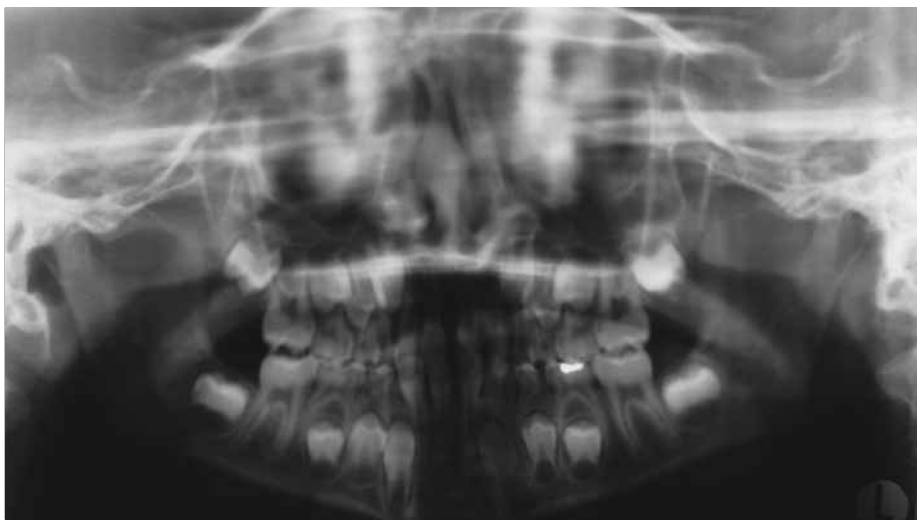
Orthopantomogram radiograph (OPT) demonstrating the 'double' deciduous tooth affecting the lower left quadrant. Note the presence of only three lower permanent incisors.
